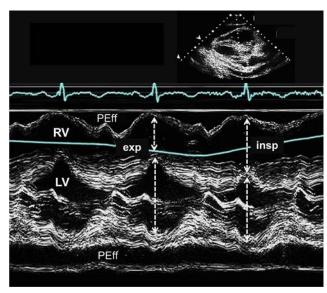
M-mode echocardiogram obtained from a patient with a pericardial effusion (PEff) and cardiac tamponade. When the right ventricle (RV) enlarges with inspiration (insp), the left ventricle (LV) becomes smaller (dashed arrows). The opposite changes are seen on expiration (exp).
